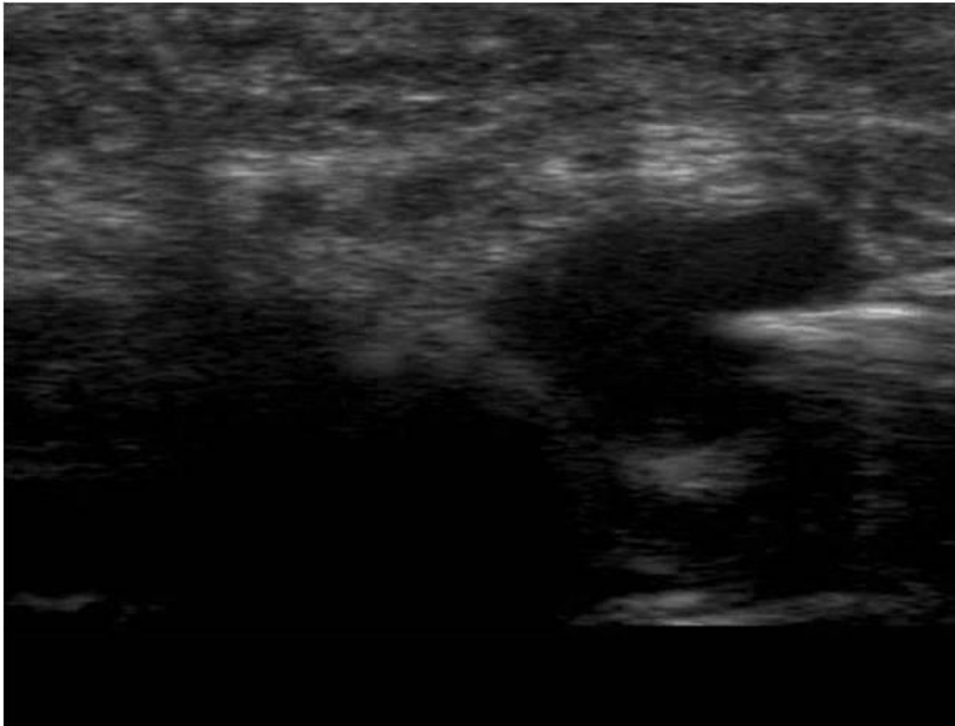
Ultrasound appearance of a ganglion cyst
